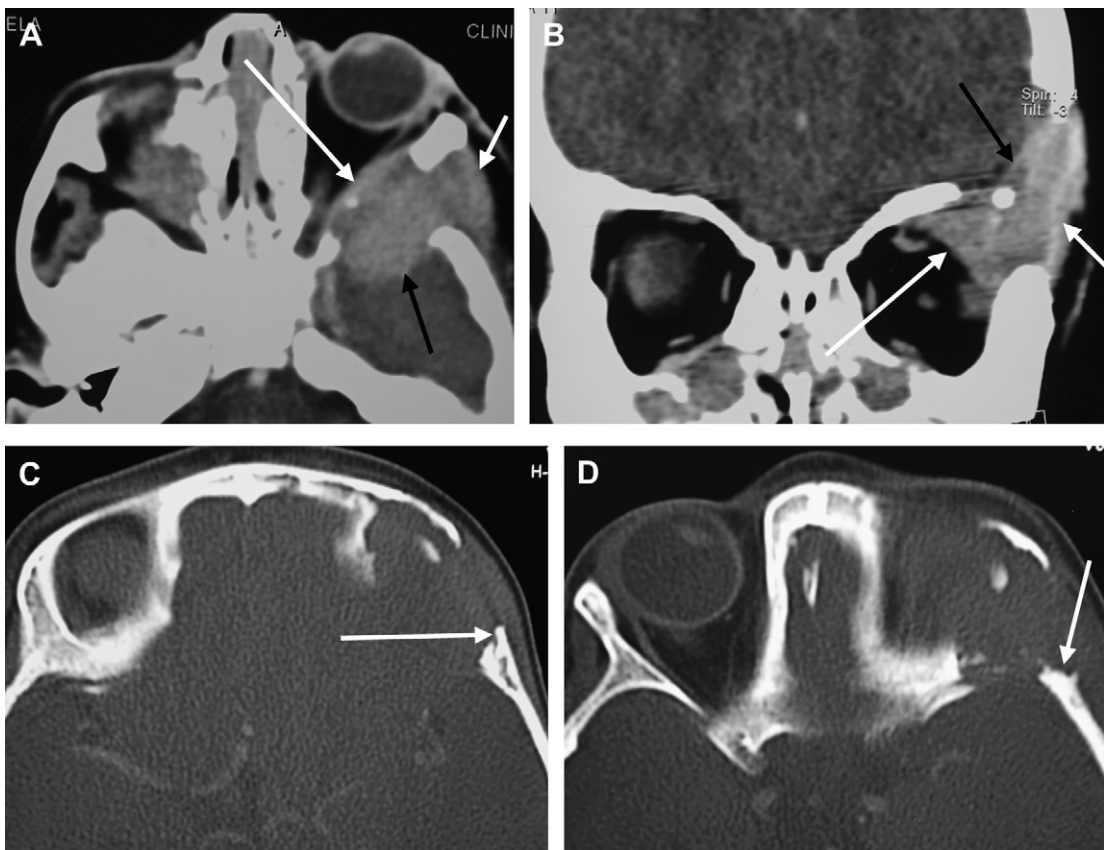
Contrast-enhanced axial (A) and coronal (B) CT images in soft tissue window show a vividly enhancing mass lesion on the left sphenoid triangle bulging medially into the orbit (*long white arrows*), laterally into the suprazygomatic masticator space (*short white arrows*) and posteriorly into the middle cranial fossa (*black arrows*). Axial images on a bone algorithm (C and D) show a lytic expansile lesion with bevelled edges (*white arrows*) in a 9 month old child (Langerhans cell histiocytosis).
